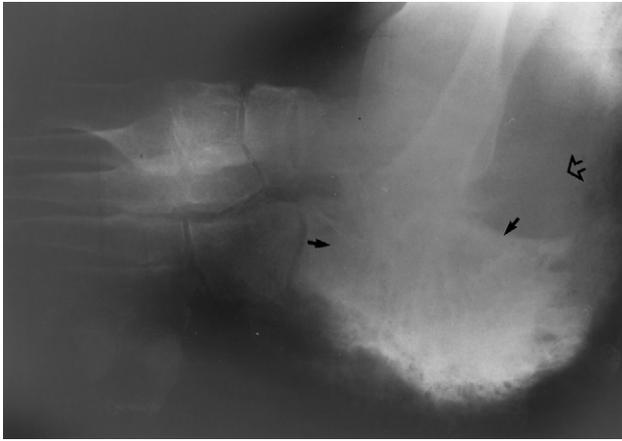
Mycetoma of the foot in a patient with chronic soft tissue swelling and draining sinuses. Lateral radiograph shows marked sclerosis and irregularity of the calcaneus (arrows). Although confined to a single bone in this case, mycetoma may involve several bones. A joint effusion is also noted (open arrow). When there are draining sinuses the causative fungal organism can be recovered from the discharged contents. (Case courtesy of Dr Rajendra Kumar, Houston, TX.)
